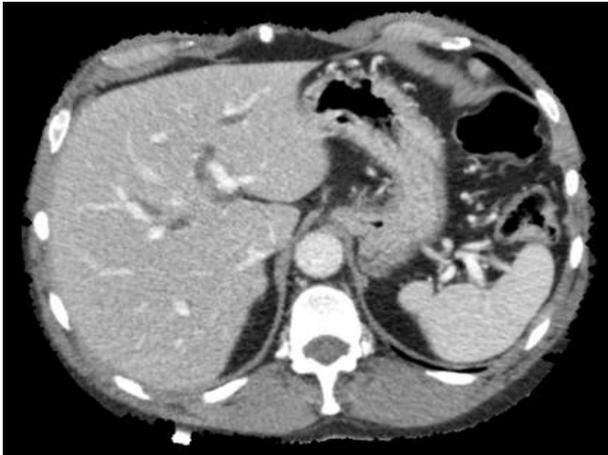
CT scan showing bile duct dilatation
